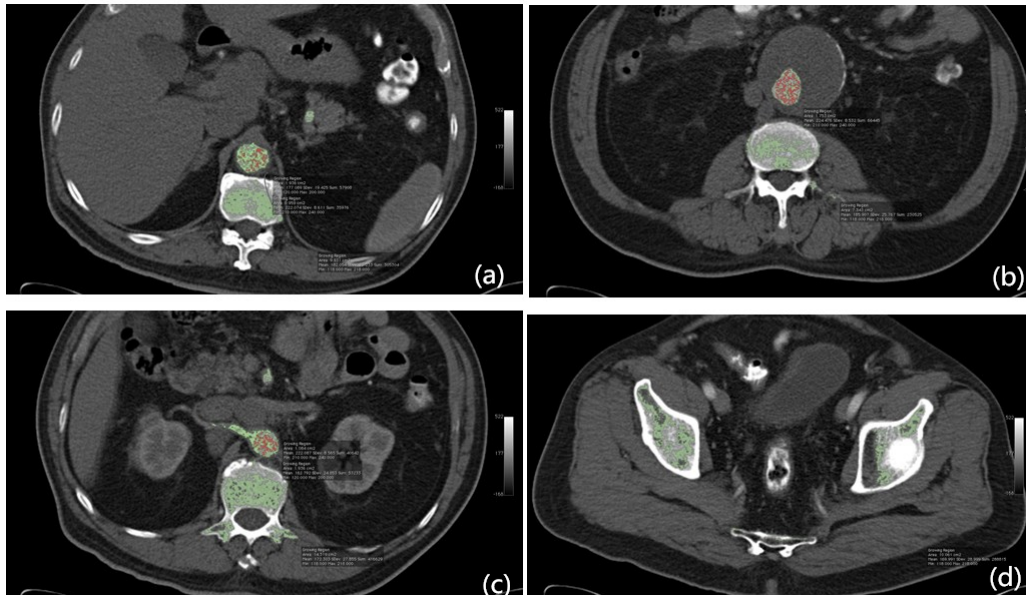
CT-images of aorta in four different layers.
